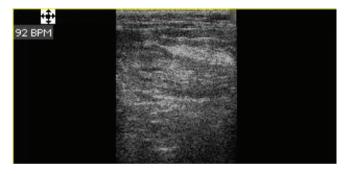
Longitudinal sonogram of jejunal intussusception
